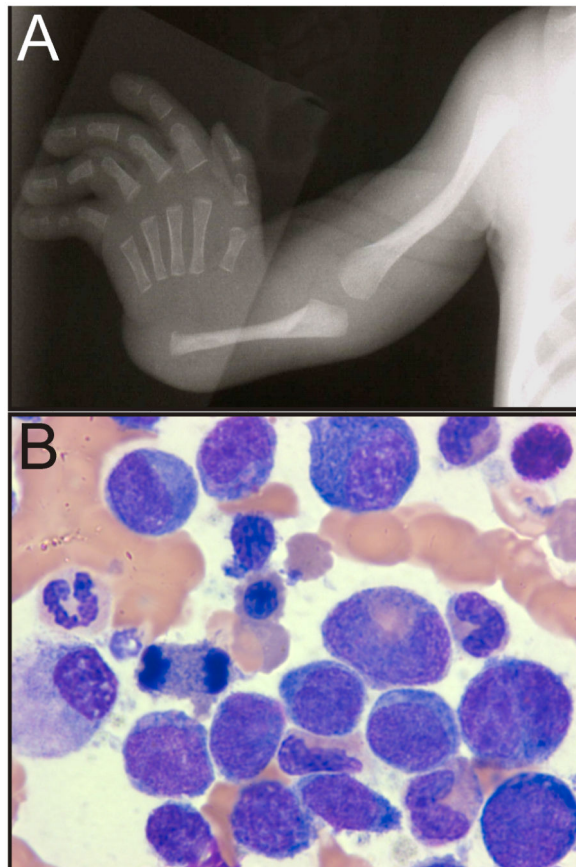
Phenotypic features of TAR syndrome. (A) Absence of the radius. (B) Late-onset MDS in an adolescent with TAR syndrome (see Vignette 6). Radiograph courtesy of William H. McAlister, M.D.
